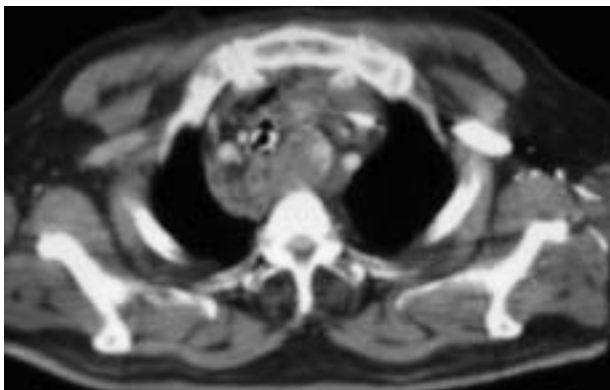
Thoracic computed tomography scan revealing mediastinal involvement.
